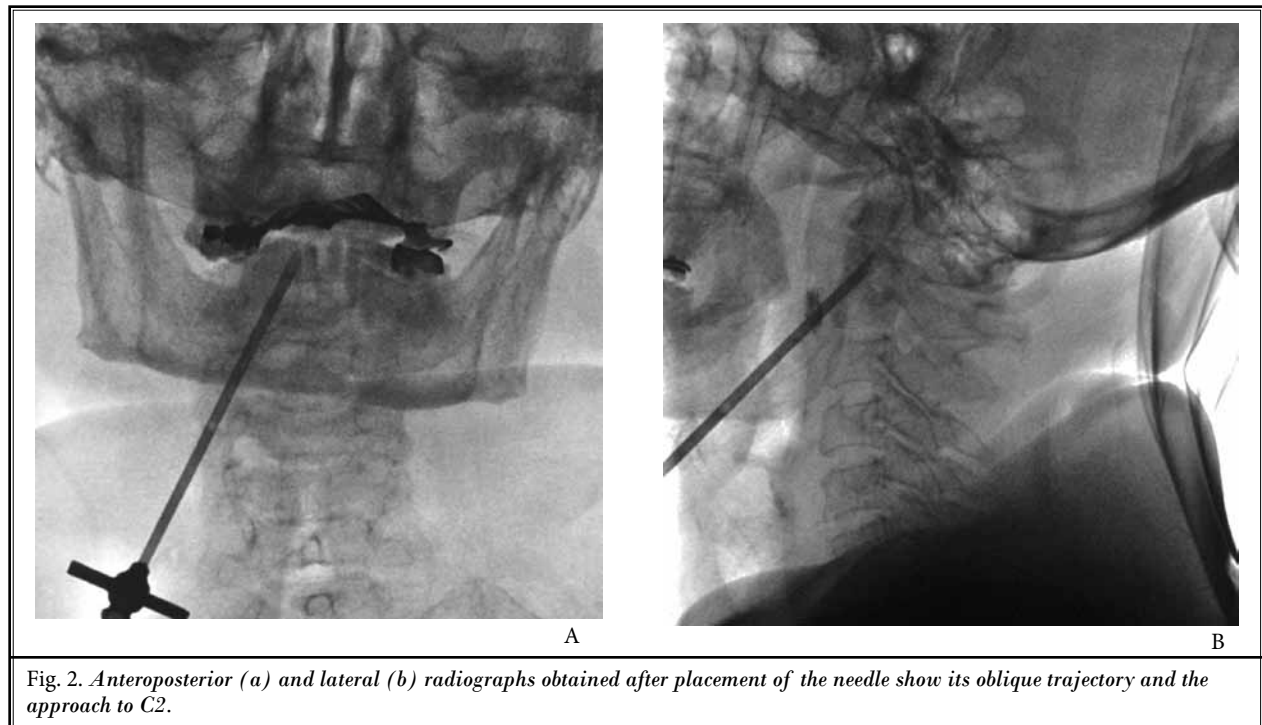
Anteroposterior (a) and lateral (b) radiographs obtained after placement of the needle show its oblique trajectory and the approach to C2.
